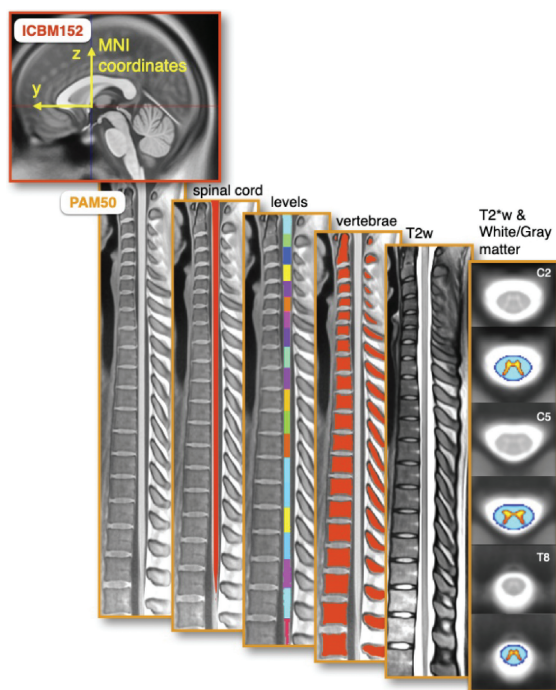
PAM50 MRI template of the full spinal cord and brainstem. The PAM50 template is compatible with the ICBM152 brain template (the MNI template), allowing researchers to conduct simultaneous brain/spine studies within the same coordinate system. The PAM50 template includes atlases of white matter pathways, gray matter subregions, and probabilistic spinal levels (adapted from <https://spinalcordtoolbox.com>, with permission).
